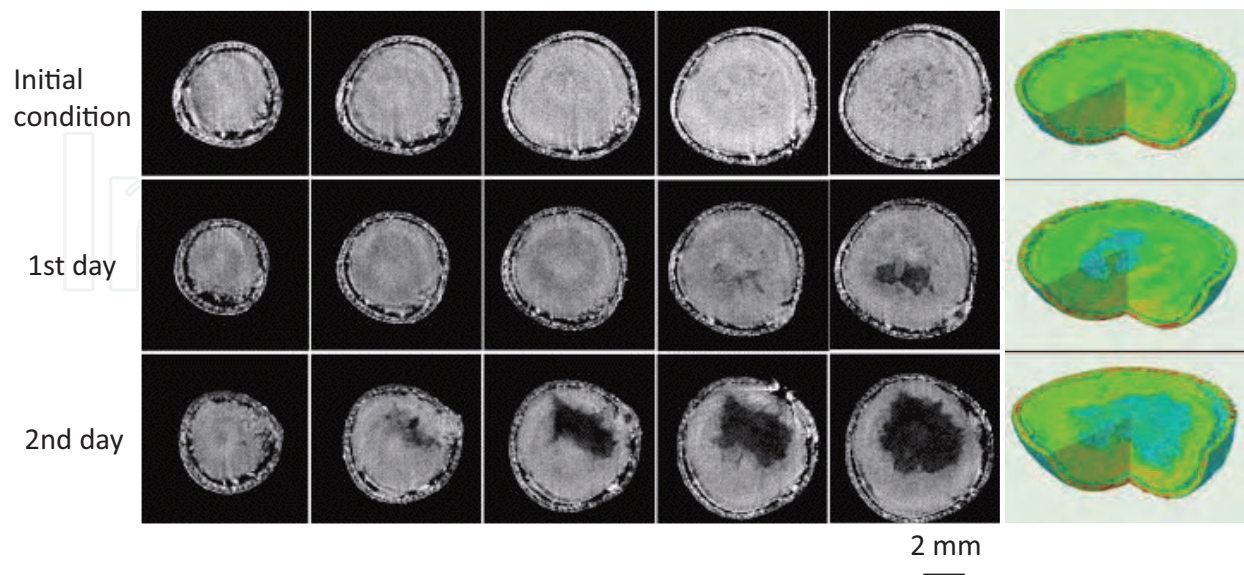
Series of horizontal slice images of colon cancer and 3D in-vivo phase-contrast X-ray CT images taken before and after anti-cancer drug therapy started.
